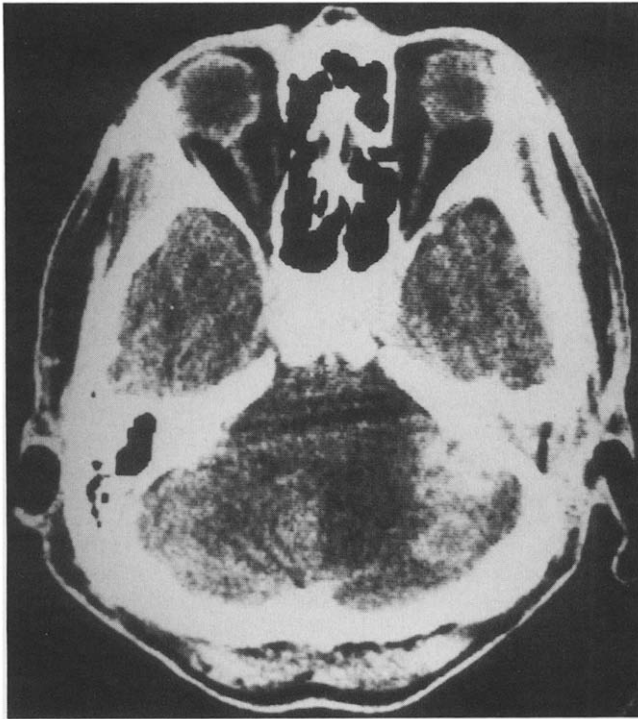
Contrast-enhanced CT scan of case 2. Two abscesses are conglomerated at the left cerebellopontine angle. The adjacent left petrous bone lost its air content.
